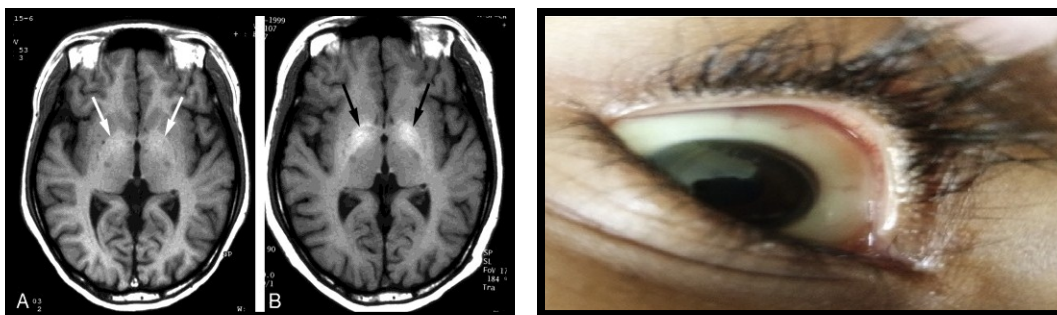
CT Scan of Brain and KF ring
